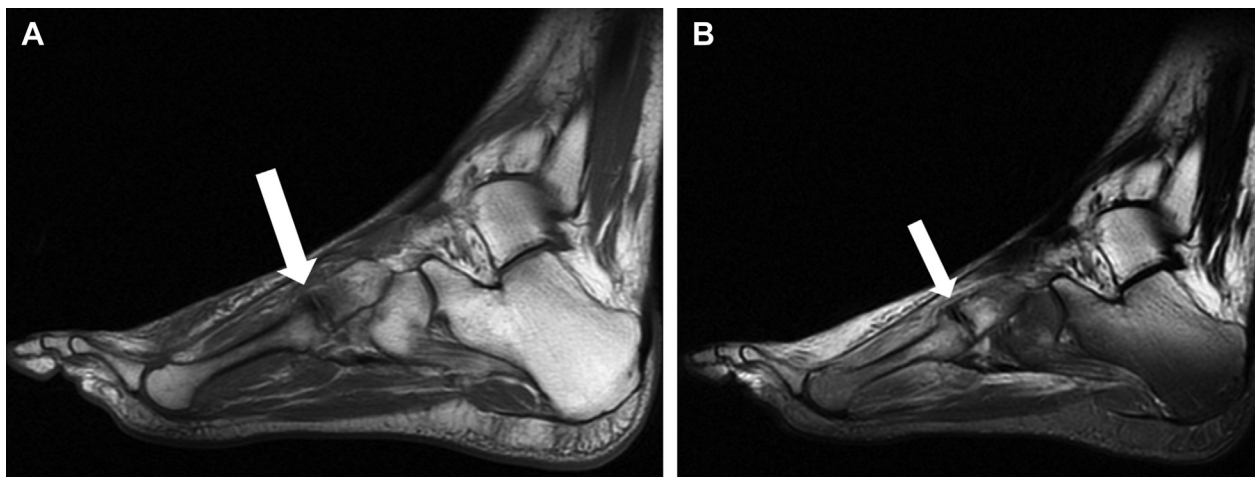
T1- (A) and T2- (B) weighted magnetic resonance images of the left foot. The arrows show subchondral fractures of the 3rd metatarsal and lateral cuneiform adjacent to the tarsometatarsal joint with extensive surrounding bone and soft tissue edema.
